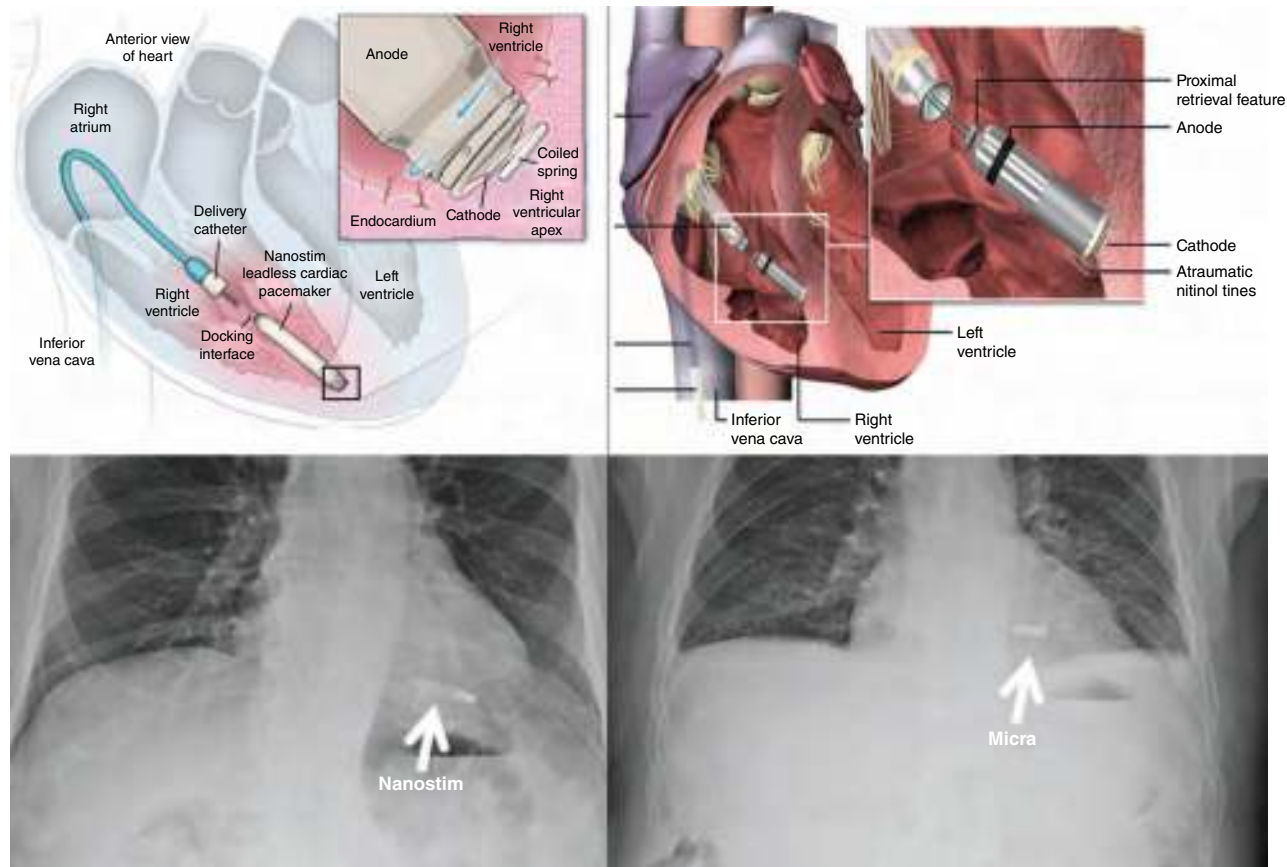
Leadless pacemaker fixation mechanism and radiographic appearance. Nanostim active fixation leadless pacemaker (St. Jude Medical, St. Paul, MN) is on the left and the Micra passive fixation transcatheter pacing system (Medtronic, Minneapolis, MN) is on the right. (Used with permission from reference 30.)
